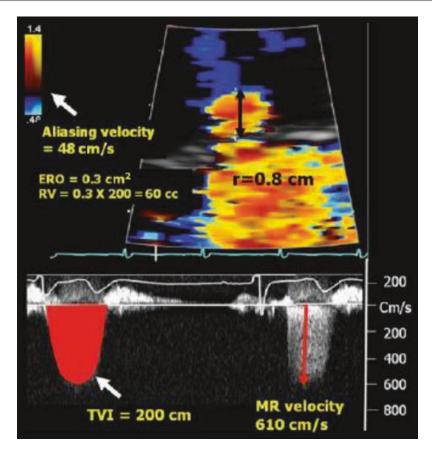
This figure shows the PISA methods to evaluate the severity of MR. The PISA is obtained from the apical 4-chamber view. The baseline is shifted downward toward the regurgitant jet flow (*arrow*). Then the PISA diameter is measured from the surface of the hemisphere to the narrowest area on color Doppler (0.8 cm). The CW
